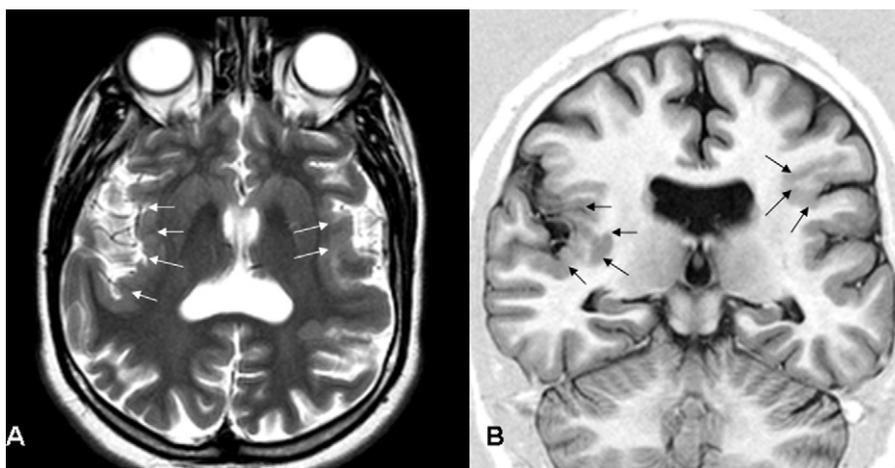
(A) axial T2-weighted image and (B) coronal IR sequence showing a case with bilateral perisylvian polymicrogyria.
